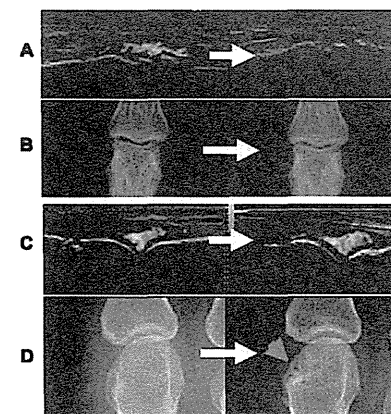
The change in synovial vascularity and bone destruction. In the left second proximal interphalangeal joint, images for synovial vascularity improvement (baseline to eighth week) (A) and halting radiographic progression (baseline to twentieth week) (B) are shown. In the right second metacarpophalangeal joint, images for synovial vascularity persistence (baseline to eighth week) (C) and radiographic progression (baseline to twentieth week) (D) are shown. White arrows show the time course. The red arrow indicates the occurrence of bone erosion.
